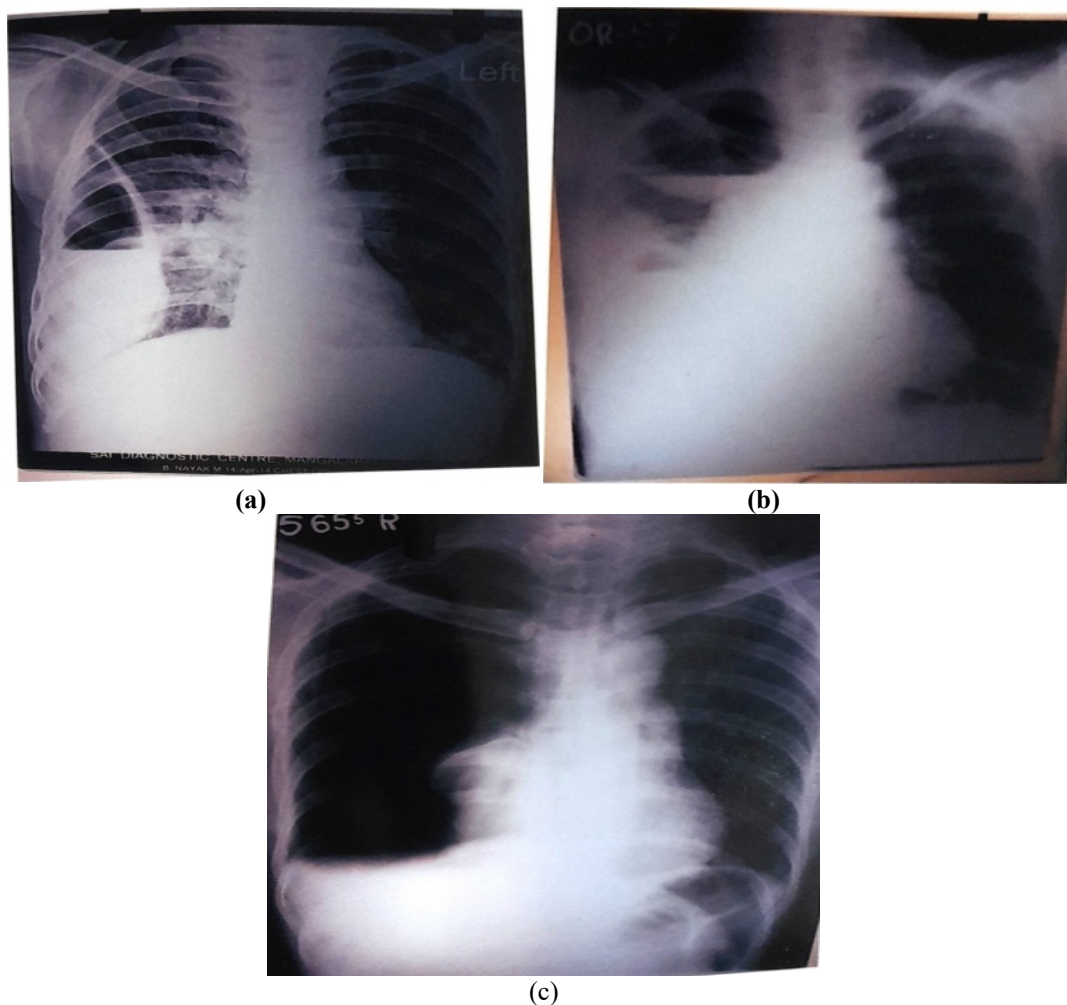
Chest X-ray PA view of (a) Uniloculated, (b) Multiloculated and (c) Free moderate Pyopneumothorax with underlying lung disease
